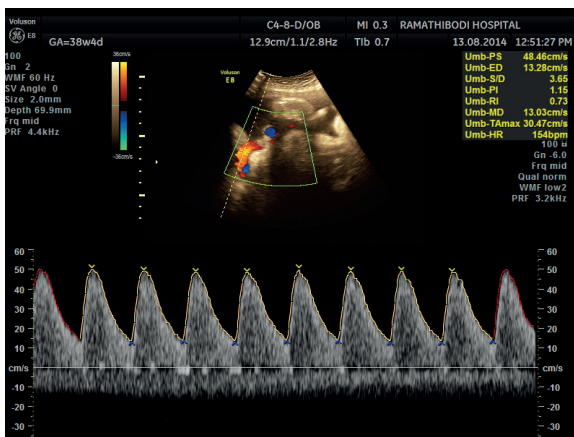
Measurement of umbilical artery Doppler at free loop.
